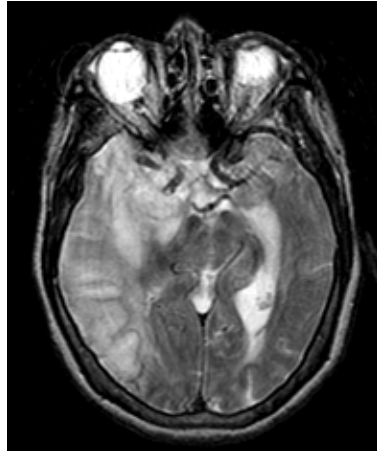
T_2 weighted magnetic resonance image.
